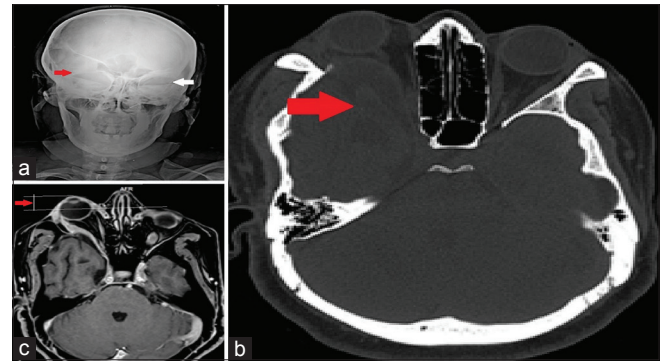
(a) Skull anteroposterior radiograph showing the absence of right innominate line (red arrow). (b) Axial computed tomography in bone window confirming the absence of right-side innominate line. (c) Axial T1-weighted image demonstrating right-sided proptosis with herniation of temporal lobe
